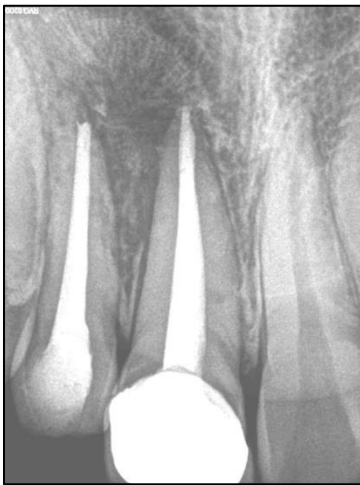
18 months follow up radiograph.
